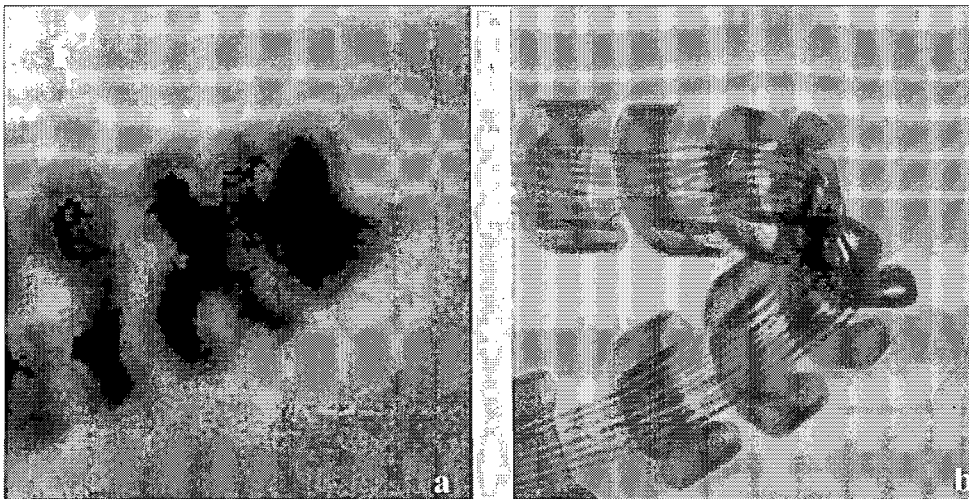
Enlargements of electrode array from a conventional radiograph (a) and a phase-contrast radiograph (b). The diameter of micro-wires was $25\ \mu\text{m}$.
